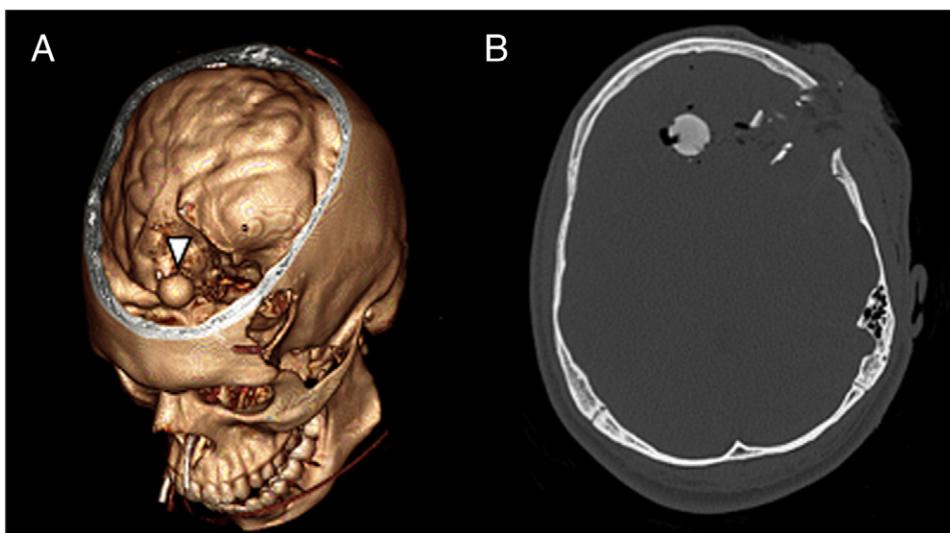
A, Three-dimensional reconstruction of the CT scan on admission; white arrow head, rubber bullet. B, Bone CT scan on admission, axial view.
